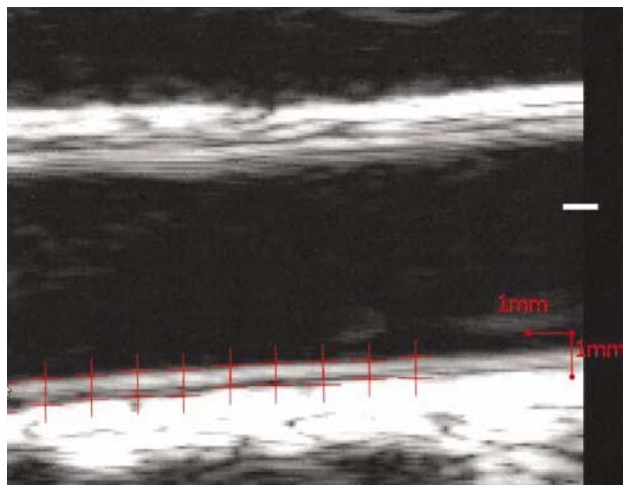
B-mode ultrasound measurement of the carotid artery (intima-media thickness). A thicker wall is associated with future vascular events. Photo reproduced courtesy of Dr. Moise Desvarieux, Columbia University, New York City, and University of Minnesota, Minneapolis.
